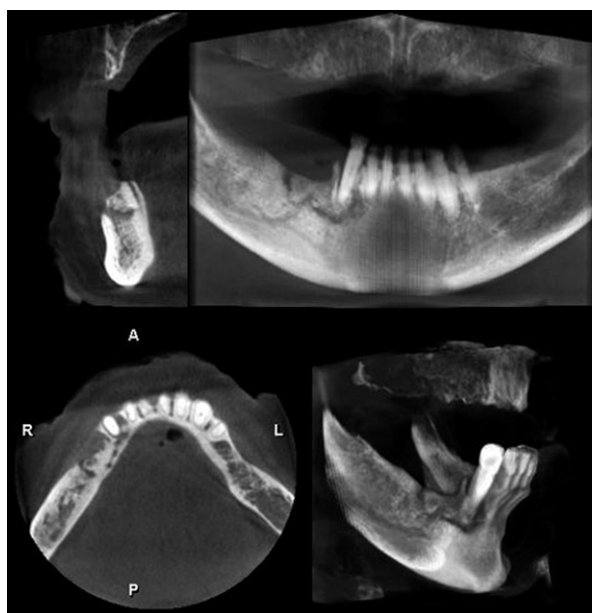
Preoperative CBCT scan.
